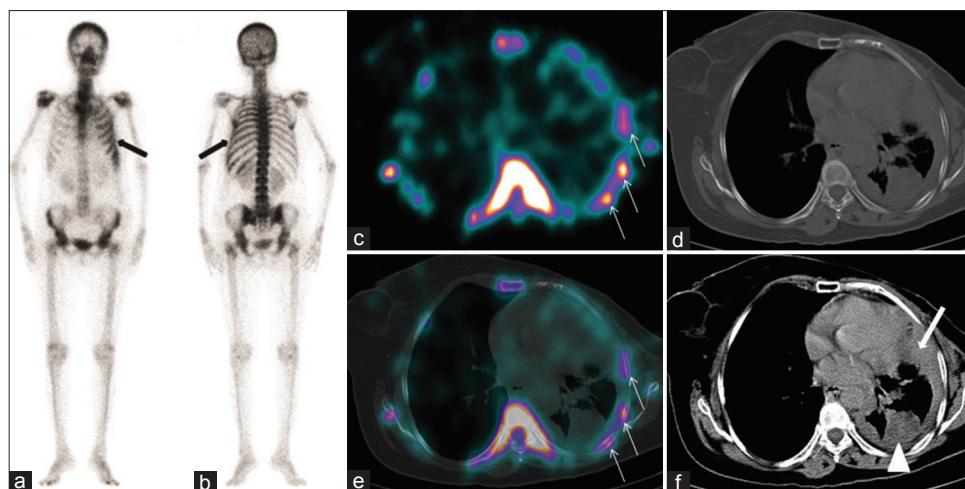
99mTc-methylene diphosphonate bone scintigraphy showing diffusely increased left rib cage uptake (anterior a, posterior b; arrows). Transaxial single photon emission computed tomography (SPECT) and SPECT/CT images (c, e; arrows) show diffusely increased radiotracer uptake involving the left-sided ribs. Transaxial CT (bone window, d) shows normal left-sided ribs with regular cortical outlines. Transaxial CT (soft tissue window, f) shows a pleural-based soft tissue density lesion in the left lung lower lobe (f, arrow head) with diffuse circumferential pleural thickening (f, arrow)
